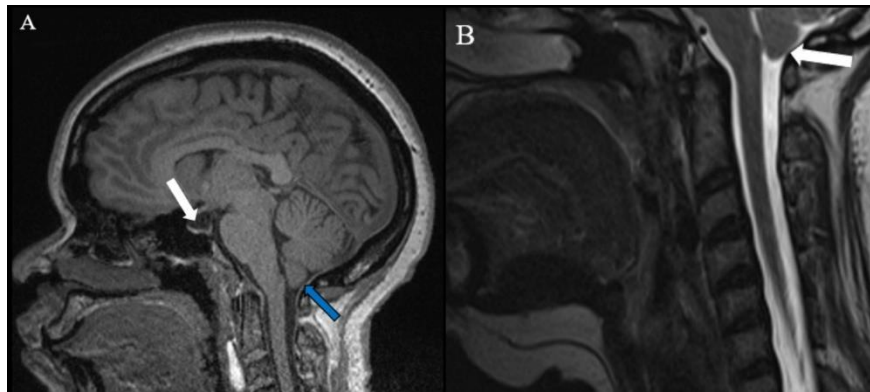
(A) T1-weighted brain MRI, sagittal view. The white arrow shows CSF-filled sella and flattened contents. The blue arrow indicates the descent of the cerebellar tonsil through the foramen magnum. (B) T2-weighted, spine MRI, sagittal view. The white arrow shows the descent of the cerebellar tonsil through the foramen magnum caudally.
